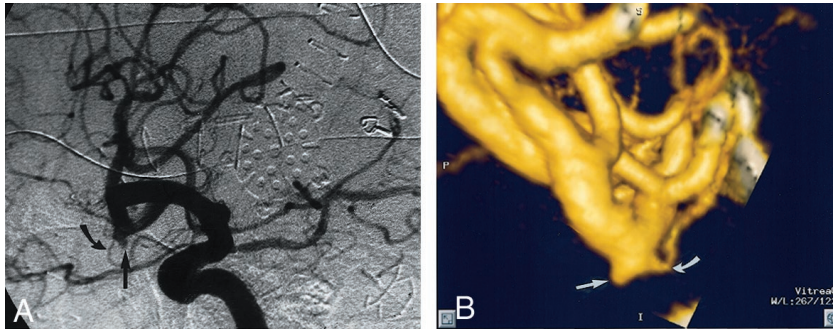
Patient 18, aneurysm 32. Example of CTA false negative (reader 1) finding.
